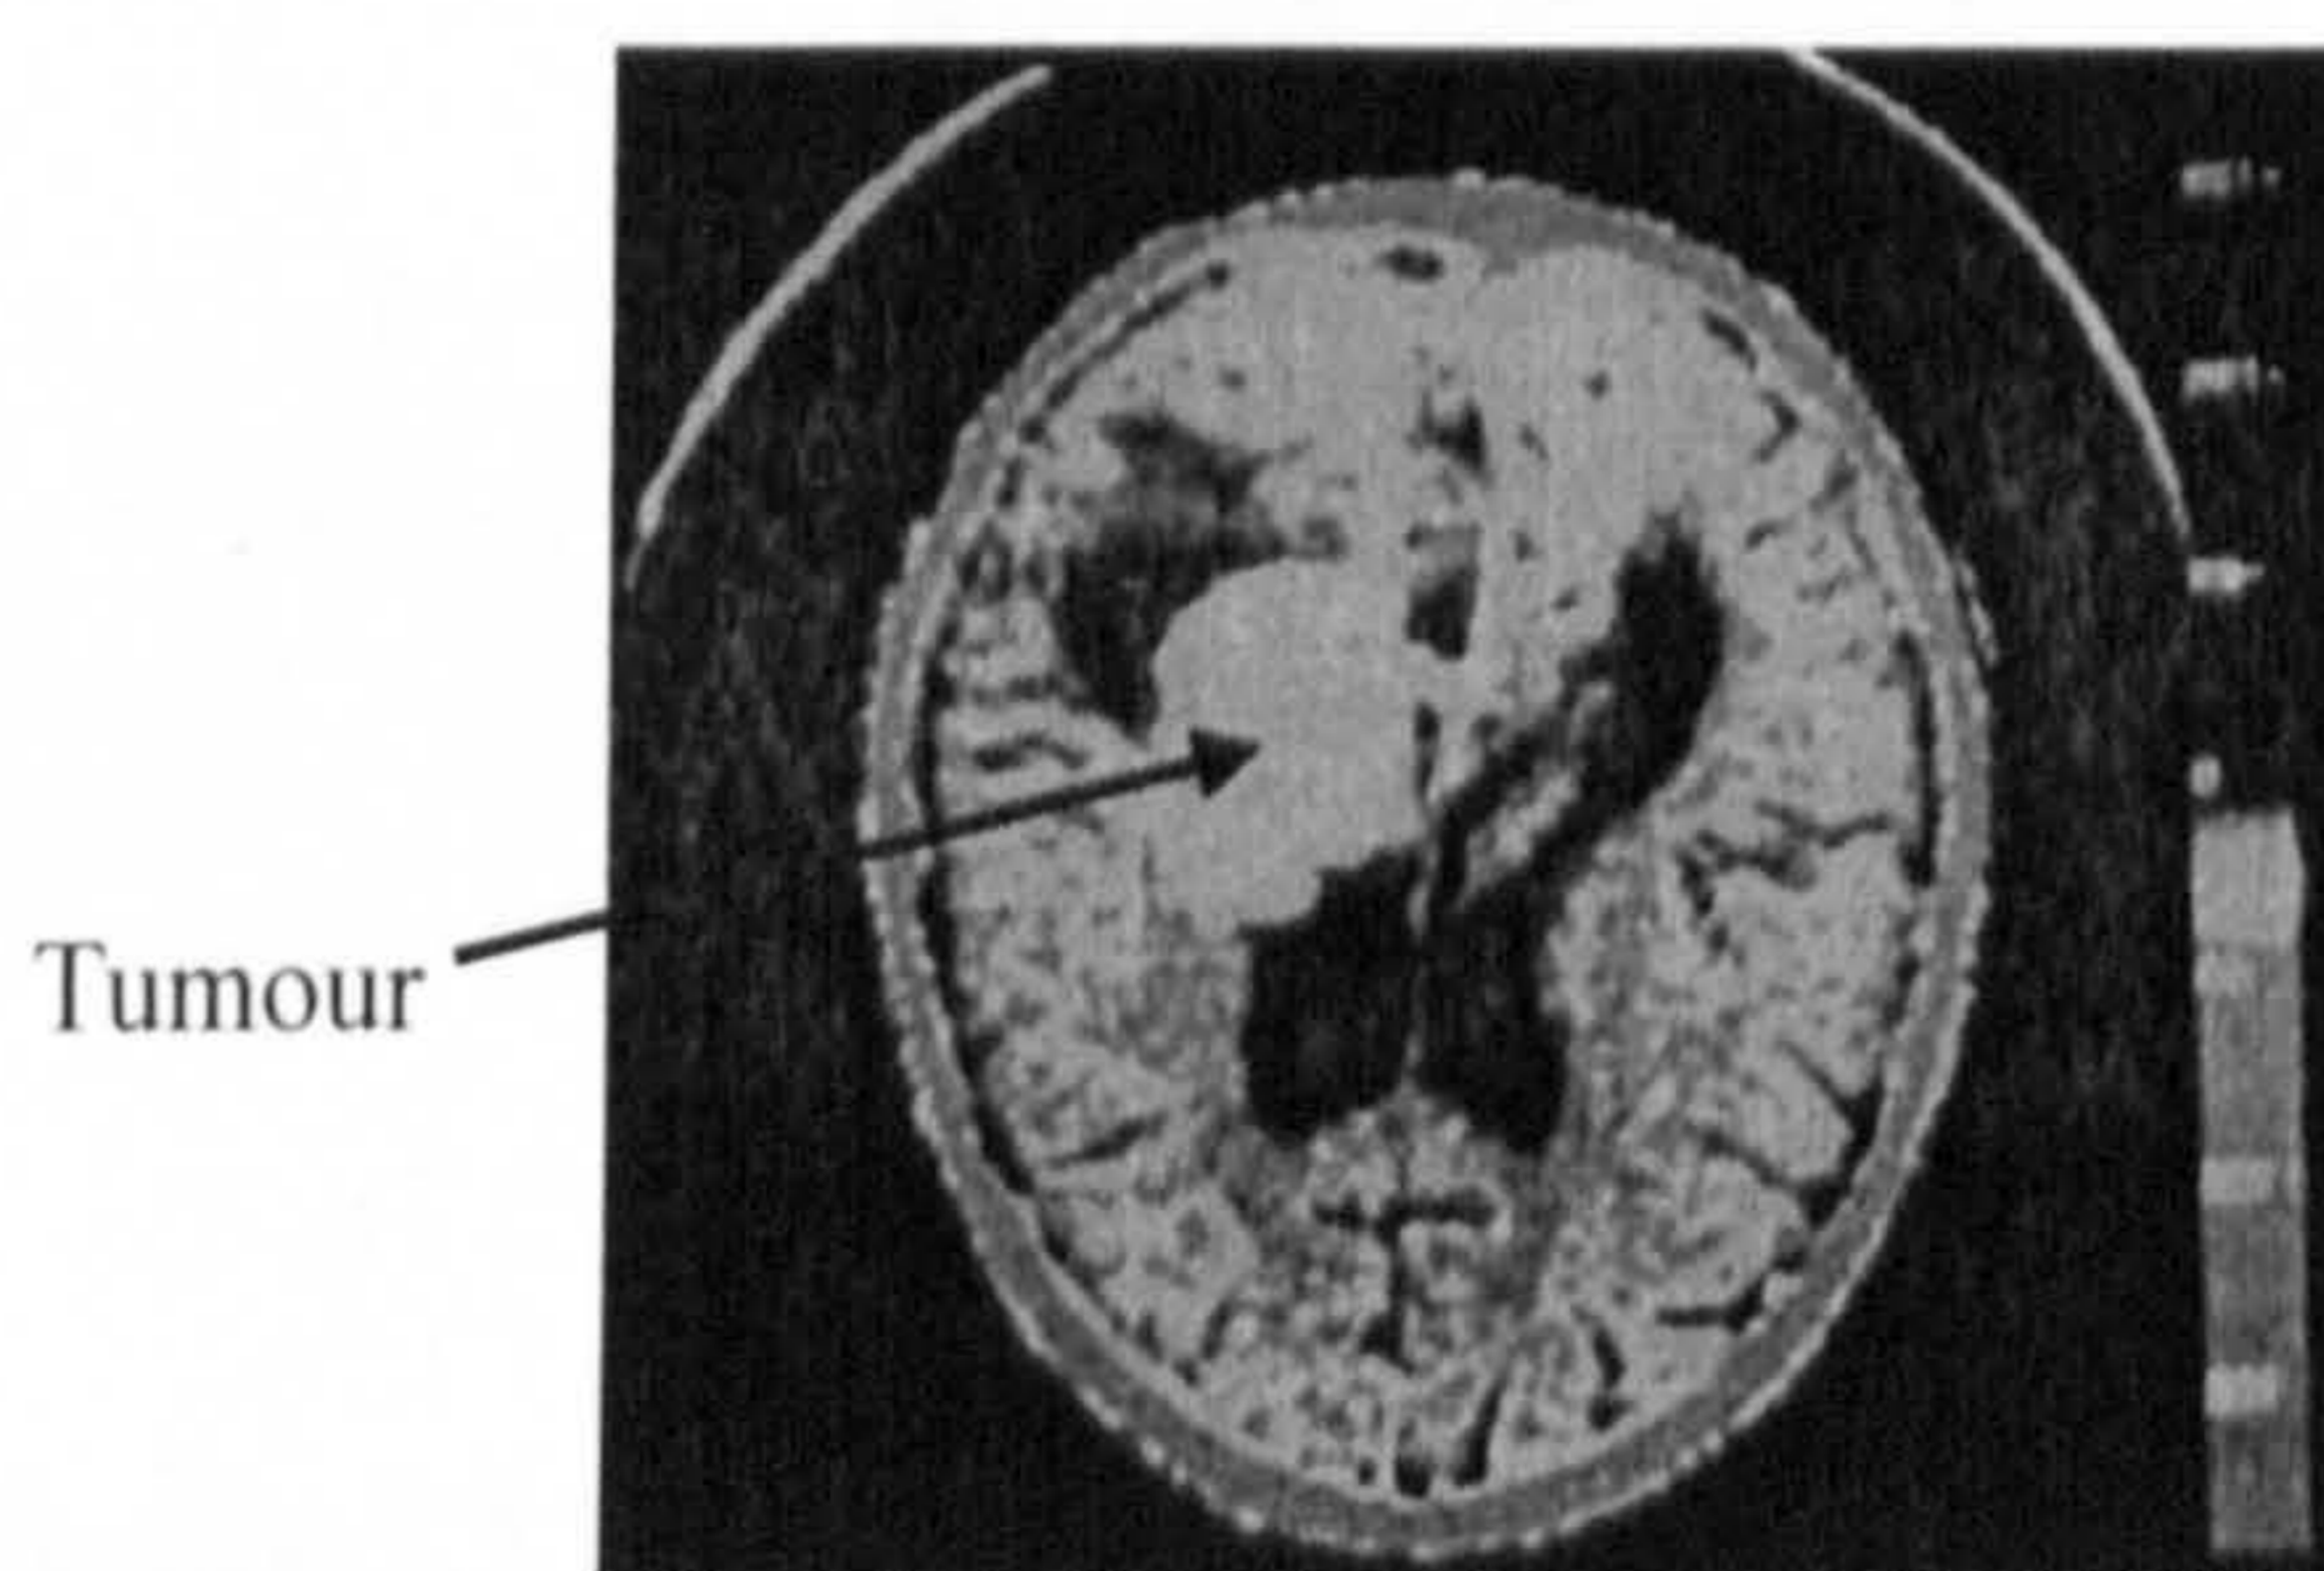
CT scan of brain tumour [Rich and Lasley 1998].
